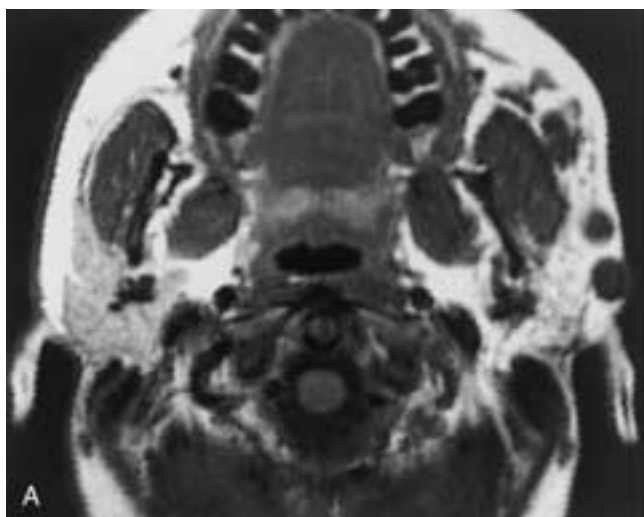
Seeding of the left buccal space from a partially resected parotid pleomorphic adenoma. A, Axial T1-weighted MR image demonstrates multiple nodules in the left buccal space. These lesions become very hyperintense on the T2-weighted image (B). Note the heavy seeding anterior to the masseter muscle and posterior to the parotid duct.
